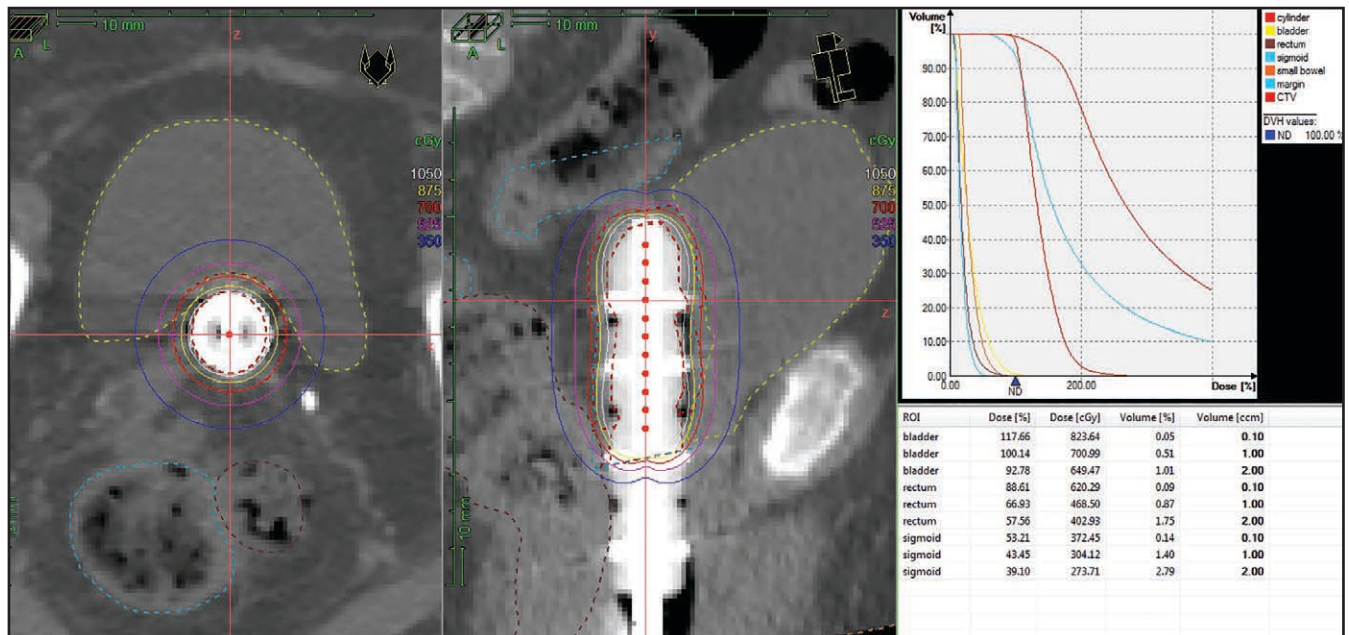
Vaginal cylinder applicator with DVH using CT-based planning for adjuvant treatment of early stage endometrial cancer.
